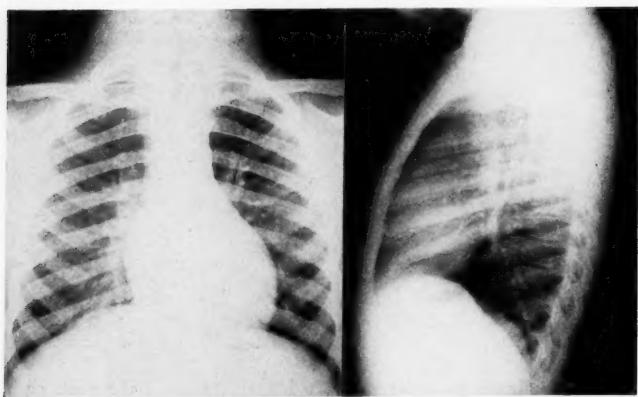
Left lateral and antero-posterior chest x-rays on the ninth postoperative day. The emphysema has absorbed and the lung fields have returned to their preoperative condition.
